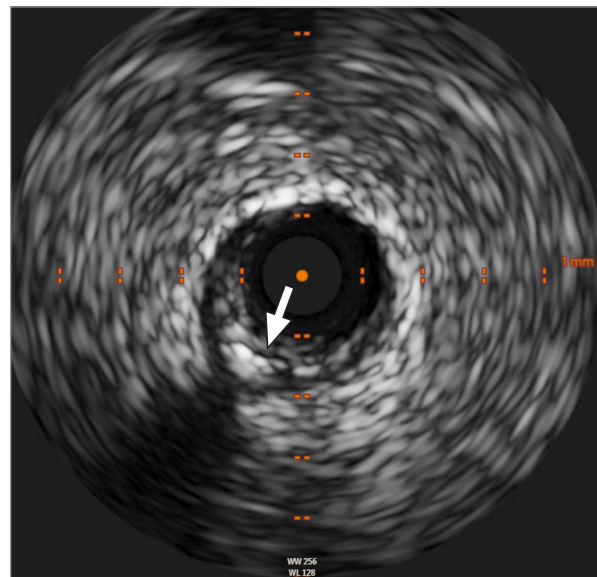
Intravascular ultrasonogram shows plaque in the left anterior descending coronary artery with erosion (arrow). Supplemental motion image available for [Figure 5](#).
